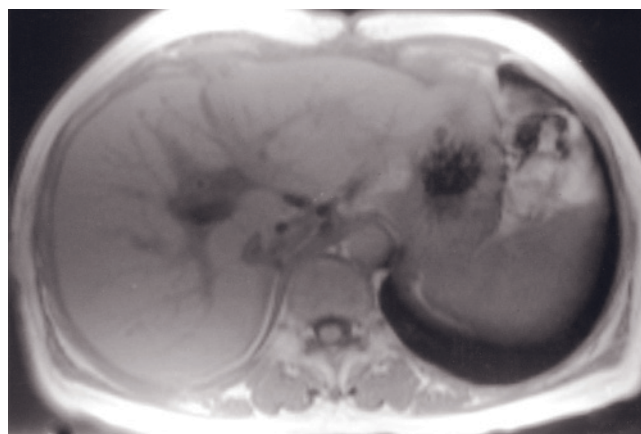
Transplanted liver recipient—lateral segment; and left lobe in a donor. T2-weighted fat-suppressed SS-ESTE (a) and SGE (b) images in a pediatric patient who had undergone liver transplantation of a lateral segment 6 years earlier. The liver has developed a rounded configuration through hyperplasia. Note a percutaneous biliary drain (arrow, a).
